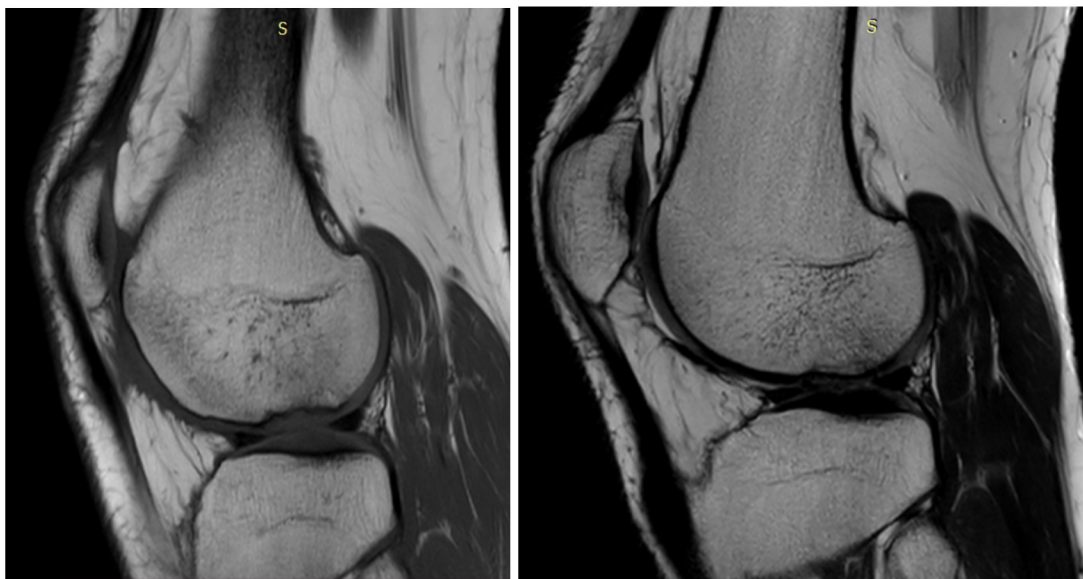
MRI of the left Knee: 12 and 24 months postoperatively
